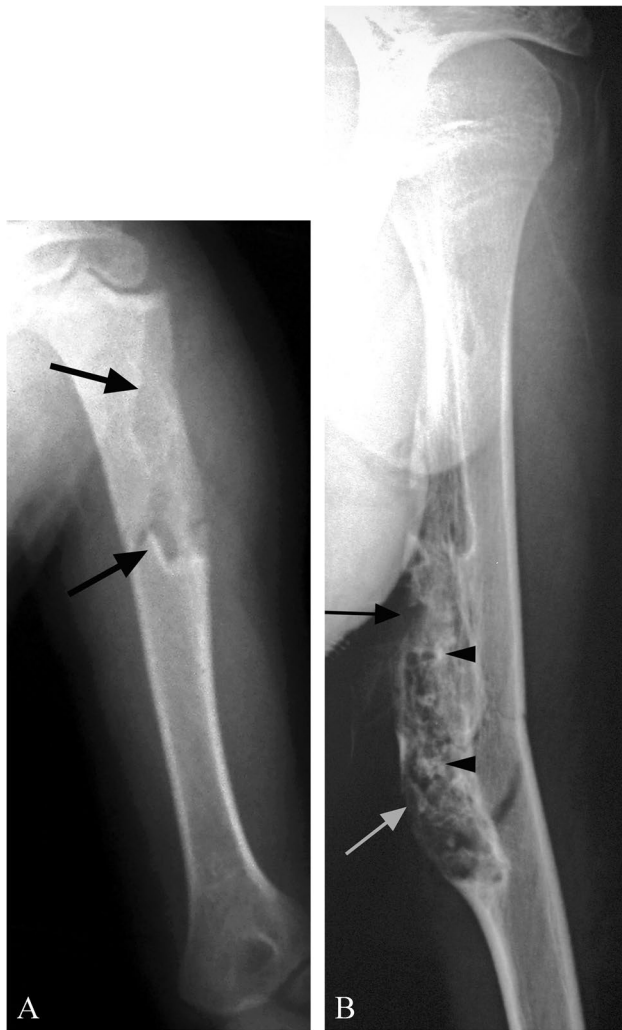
An 11-year-old patient with fibrocartilaginous mesenchymoma in the left humerus. (A) Frontal view radiograph of left humerus shows a lytic lesion with a sclerotic rim (arrows) in the proximal humeral metaphysis and diaphysis. Follow-up radiographs (B) shows the lesion's increased size, internal calcification (arrowheads), cortical destruction, and marked endosteal scalloping (arrows). Courtesy of Dr. Michael Klein
